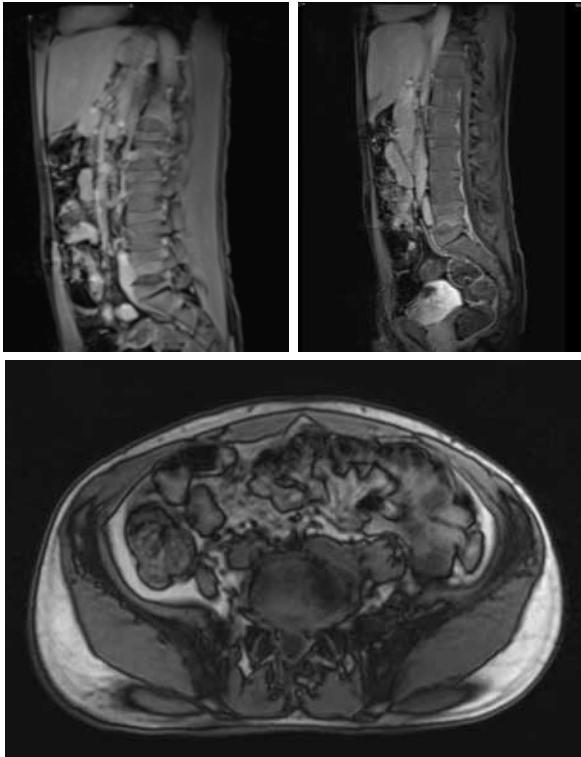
MRI Sagittal and Axial View L5-S1 intervertebral disc presented small hyper signals and irregular margins, associated with an oedema of the L5 vertebral body and a slight epidural attenuation.
